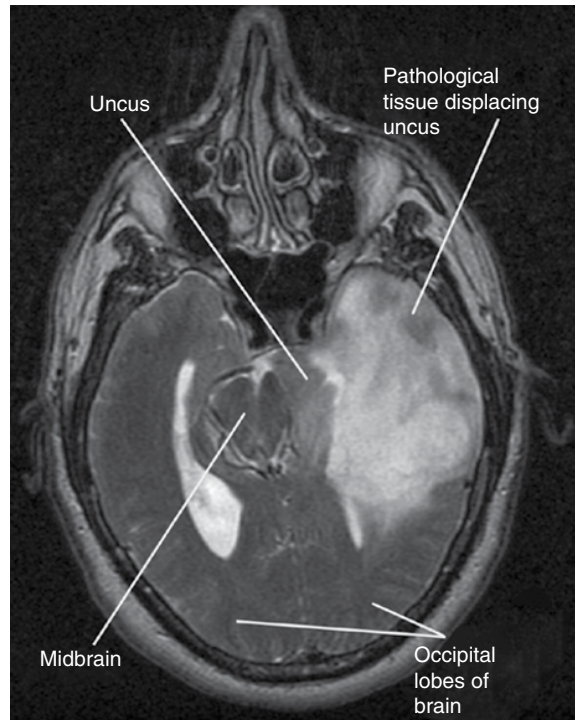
Axial MRI showing left herniation of the part of the brain known as the uncus compressing the brainstem (it is on the left because you are looking at a slice of the brain as if you were standing at the patient's feet). This patient presented with double vision. The MRI examination confirmed the cause of the double vision as compression of CN III by the uncus of the temporal lobe of the brain (see Chapter 3).
